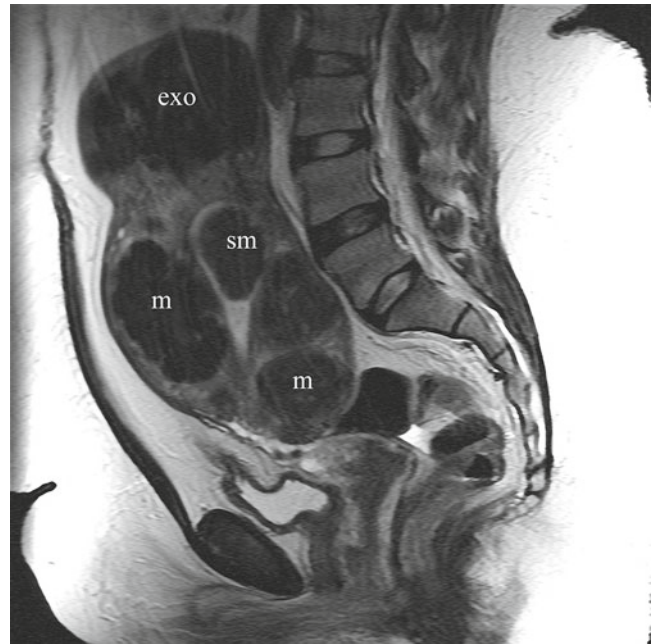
Fibroids, T2-weighted sagittal (a) and axial (b) images of multiple uterine fibroids of low signal relative to the myometrium throughout the uterus in multiple locations, including submucosal (sm), myometrial (m), and exophytic (exo). Reproduced with permission from Magen A, Veniero JC. In: Hurd WW, Falcone T, eds. *Clinical reproductive medicine and surgery*. St. Louis, MO: Mosby/Elsevier; 2007. (Fig. 31.18 from 1st ed)
